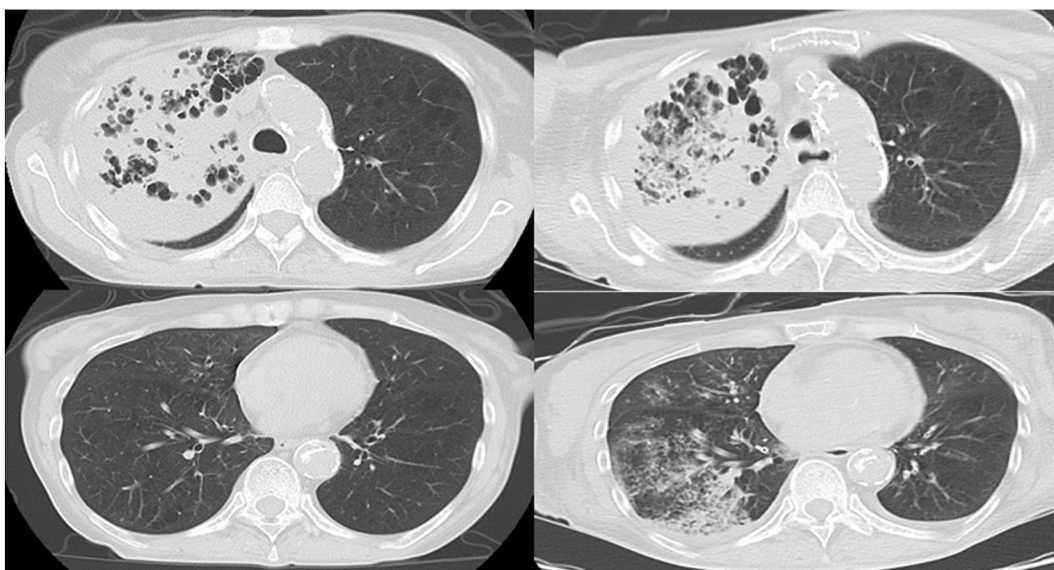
Chest computed tomography on admission (left side) and at day 4 (right side) showed new infiltration with ground glass opacity in the right lower lobe.
